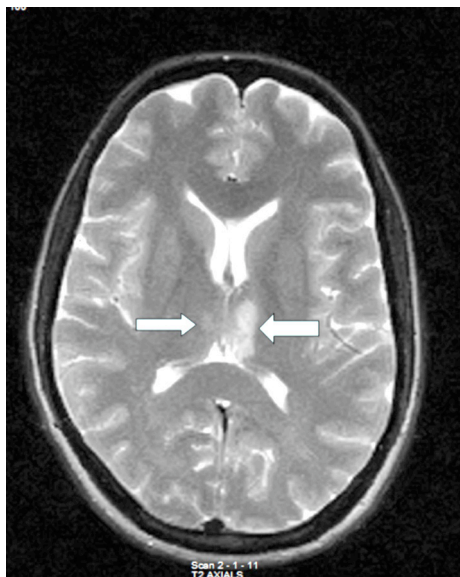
T2 magnetic resonance imaging (MRI) of the brain showing bilateral thalamic infarcts.
